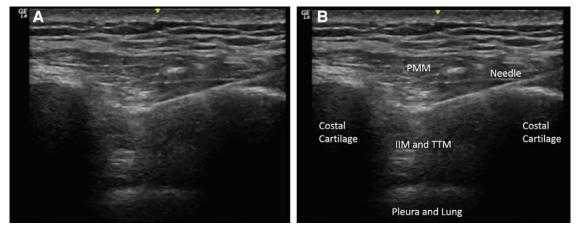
Ultrasound image of the intercostal space lateral to sternum in the sagittal orientation. A, Image without identifying labels. B, Image with identifying labels. IIM indicates internal intercostal muscle; TTM, transversus thoracis muscle; PMM, pectoralis majoris muscle.
